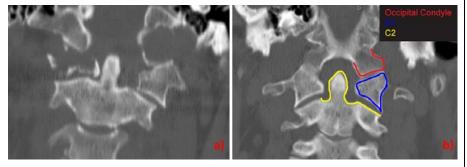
A 64 yo male presents with severe acute onset neck pain with both upper and lower extremity weakness and numbness. Coronal CT reformat demonstrates lytic metastasis to the left occipial condyle and right lateral mass of C1. Weaking of the bone has resulted in a pathologic fracture of the right lateral mass of C1 with loss of vertebral height. On further workup, a lung mass was identified and biopsy returned non-small cell lung cancer. Figure 2b is provided as comparison of normal anatomy. University of Massachusetts Medical School, Department of Radiology.
